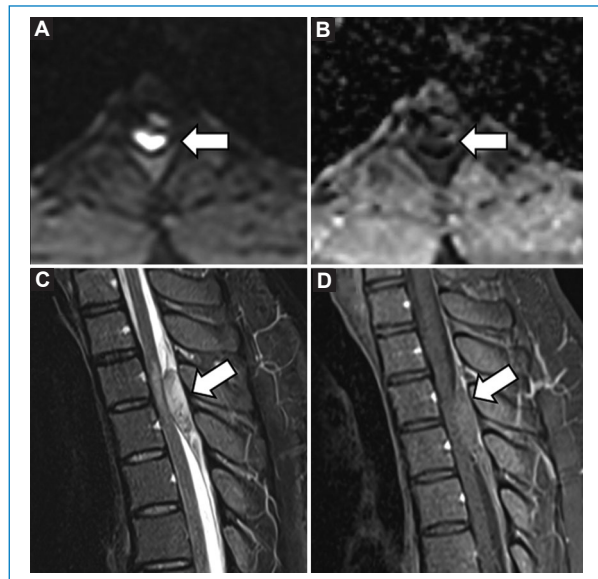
A and B: Siemens 1.5 T Axial RESOLVE diffusion. C and D: T1-weighted and T1-weighted sequences after gadolinium and with fat saturation, respectively. Posterior epidural intraspinal content (arrow) in the thoracic spine showing diffusion restriction, heterogeneous hyperintensity on T2, and absence of enhancement, consistent with a spontaneous epidural intraspinal hematoma with compressive myelopathy.
